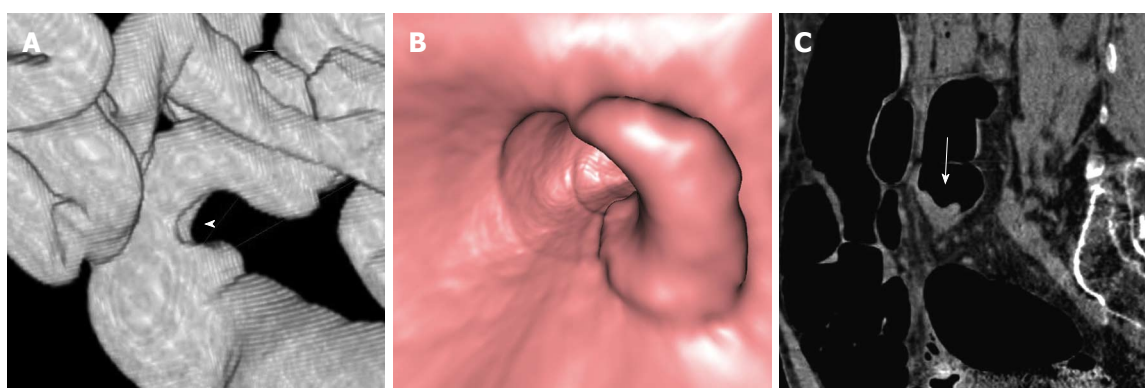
Computed tomography colonography of a T2 vegetating lesion of the sigmoid colon. A: A Computed tomography colonography (CTC) SSD reconstructed image shows a trapezoid type wall deformity of the sigmoid colon (arrowhead); B: A CTC endoluminal image demonstrates that wall involvement is less than 50% of luminal circumference. C: A CTC sagittal reconstructed image shows that the lesion (arrow) has sharp margins.
